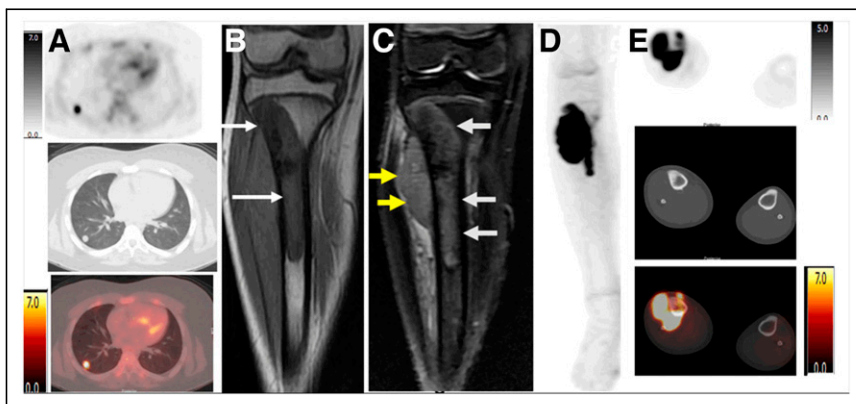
A 13-year-old boy with right leg pain. (A) ^{18}F -FDG PET CT shows 1-cm nodule with markedly elevated uptake in right lower lobe (SUV_{max} , 6.7) (^{18}F -FDG PET emission image [top], CT transmission image [middle], and PET/CT image [bottom]). (B) Hypointense signal on coronal T1 MR image shows tumor extending from tibial metaphysis through proximal third of right tibia (arrows). (C) Coronal T2 short-tau inversion recovery MR image shows intermediate signal within intramedullary component of tumor (white arrows), corresponding to hypointense T1 signal, and hyperintensity in soft-tissue component lateral to tibia (yellow arrows). (D) ^{18}F -FDG PET/CT anterior maximum-intensity-projection view shows intense uptake in the proximal aspect of the right distal lower extremity. (E) ^{18}F -FDG PET axial emission image (top), transmission CT bone window (middle), and PET/CT image (bottom) show intense though irregularly increased uptake of ^{18}F -FDG in both bone and soft-tissue components of tumor (SUV_{max} , 15.7TM).
